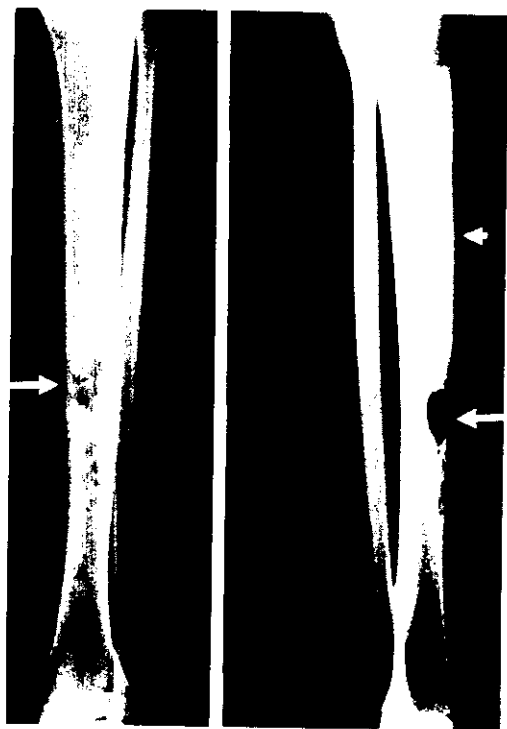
Case 2. AP and lateral roentgenograms showing a larger and some smaller multifocal lytic lesions involving the tibial middiaphysis. The cortex above the lytic lesion shows evident sclerosis and a small radiolucent lesion at the upper one-third of the tibia (arrowhead).
